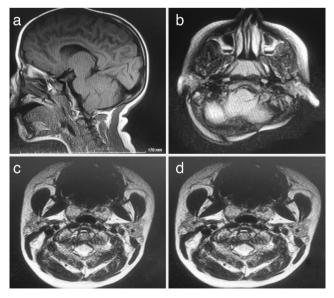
(a,b,c,d) Magnetic resonance imaging shows any residual mass lesion at the left posterior fossa of cranium after 5 years of chemotherapy.
